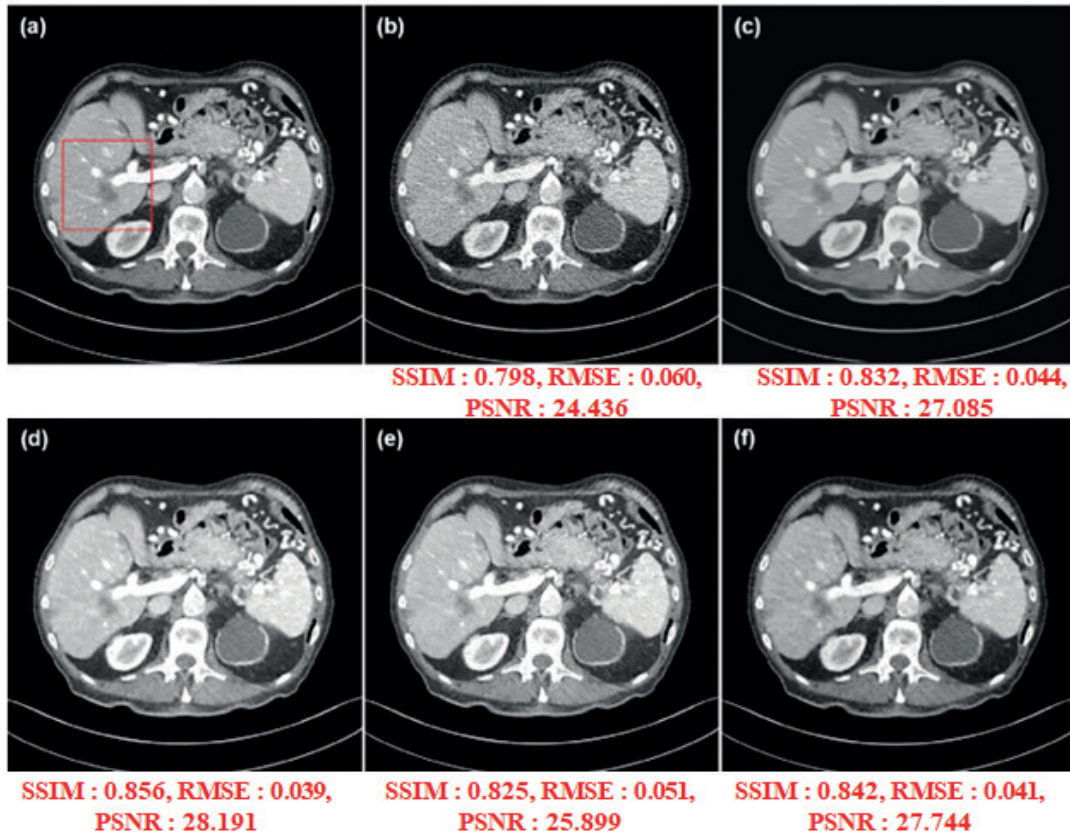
Maximum Dose of Computed Tomography (a) CT Dosage of 25 % (optional clause) (b) BM3D (b) RED-CNN (d) WGAN-VGG (e) Q-AE (f) Proposed model
